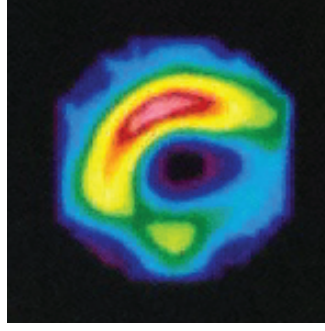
Clinical imaging modalities for modeling ventricular geometry. Examples of each different imaging modality used in this study: CT – computed tomography; MR – magnetic resonance; SPECT – Single-photon emission computed tomography.
